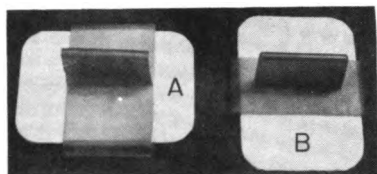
A—Posterior bitewing film. B—Anterior bitewing film.
